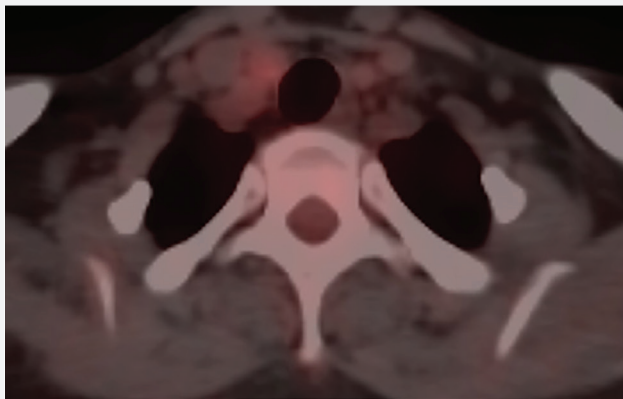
Diffuse, mild increased FDG uptake in the right subclavian artery, axial plane, PET/CT
